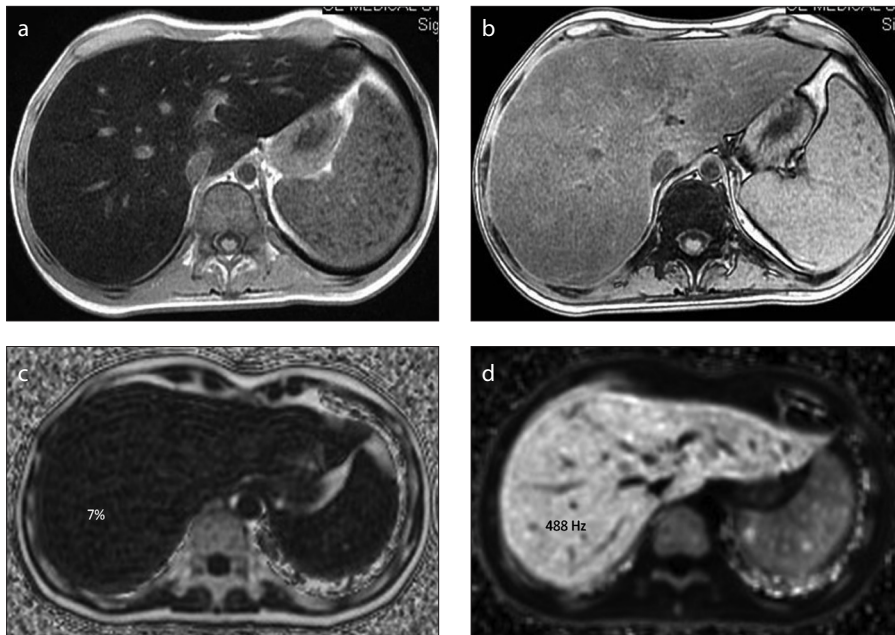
a–d. MRI of a patient with lymphoma show signal drop on in-phase image (a) relative to out-of-phase image (b) consistent with diffuse siderosis. However, measurements from proton density fat fraction map (c) and R2* map (d) show coexistence of mild steatosis (7%) and severe siderosis.
